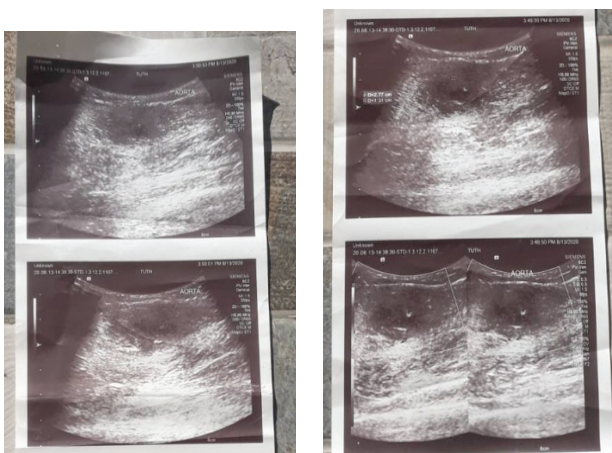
Ultrasound of the lesion
